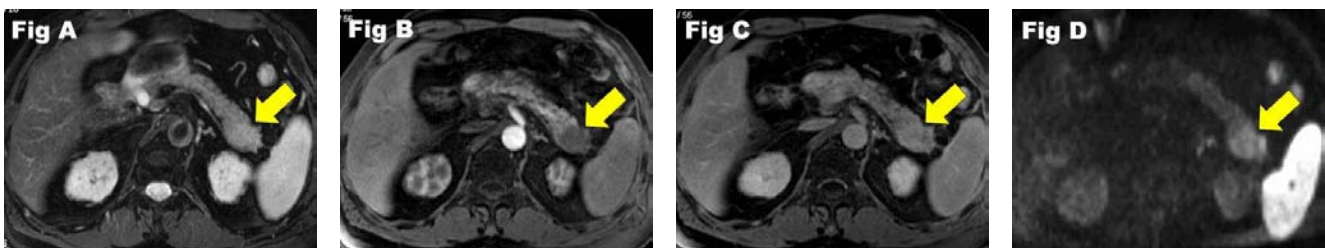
Adenocarcinoma the pancreatic tail in a 65-year-old man. The lesion (yellow arrow) showed mildly hyperintense on fat saturated T2WI (Fig A), decreased per 发 usion on arterial phase image (Fig B), delayed enhancement on equilibrium phase image (Fig C), and moderately hyperintense on DWI (Fig D). The ADC value of the lesion was $1.03 \times 10^{-3} \text{mm}^2/\text{s}$. An adenocarcinoma was confirmed by surgery.
